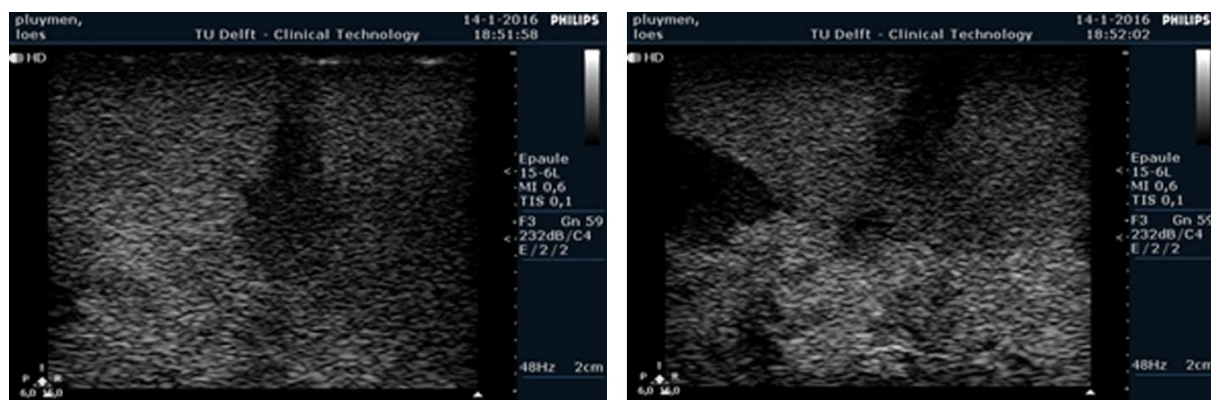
Ultrasound visualization PVA 7% 3FT : Images obtained with 2 cm penetration depth
